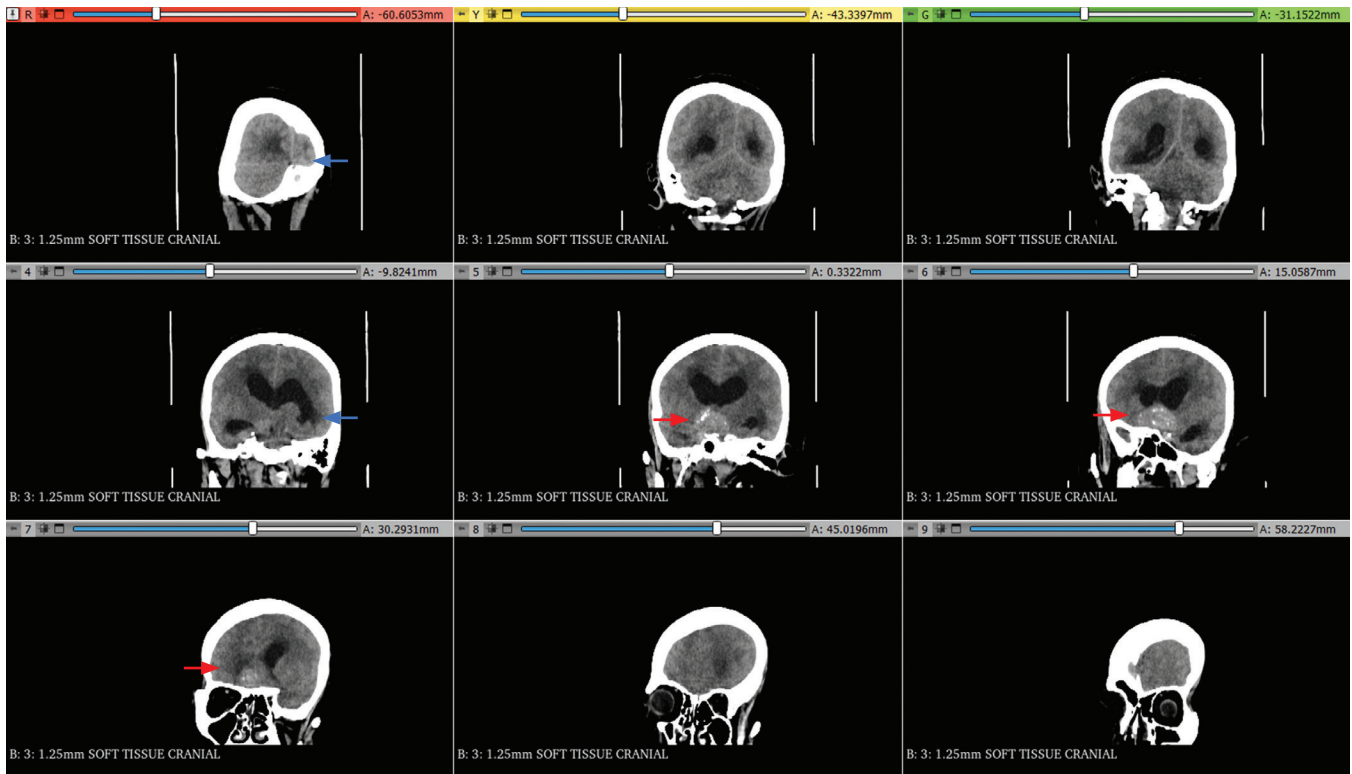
Coronal view cranial CT scan with contrast. Sellar supra-sellar mass marked by red arrows. Possible transtentorial herniation marked by blue arrows.
